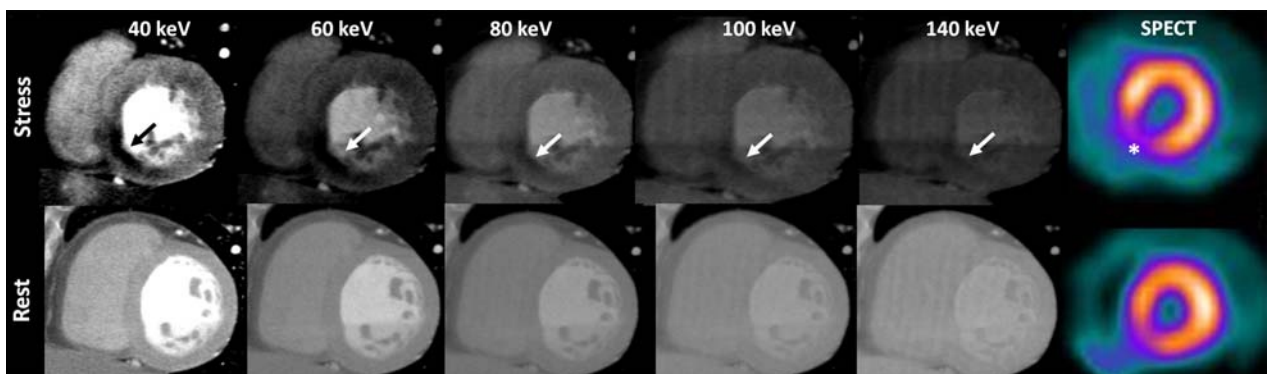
A 48-year-old woman, with hypertension, hypercholesterolemia, and smoking as coronary risk factors. Heart rate at stress was 78 beats per minute, and heart rate at rest was 61 beats per minute. A reversible perfusion defect at the inferoseptal left ventricular wall (arrows) is observed more clearly at the lower energy levels, with almost complete normalization at rest. Single-photon emission CT images confirm the findings (*). Figure 2 can be viewed online in color at www.jcat.org.
